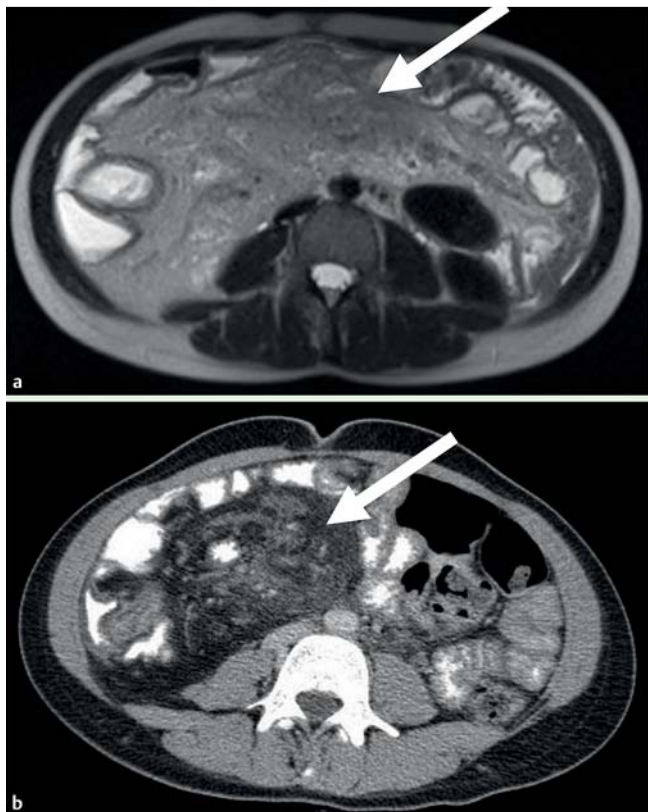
Cross-sectional images suggesting abdominal malrotation (arrows). a Magnetic resonance enterography. b Computed tomography.
